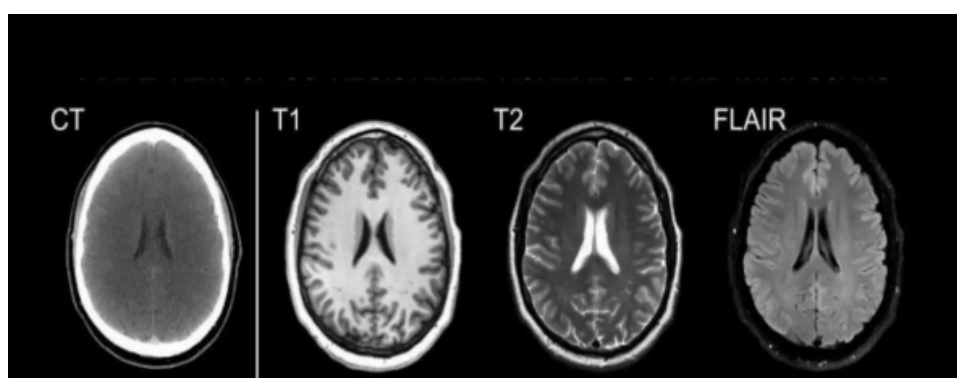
Comparison of Brain Imaging Modalities and MRI Sequences.
